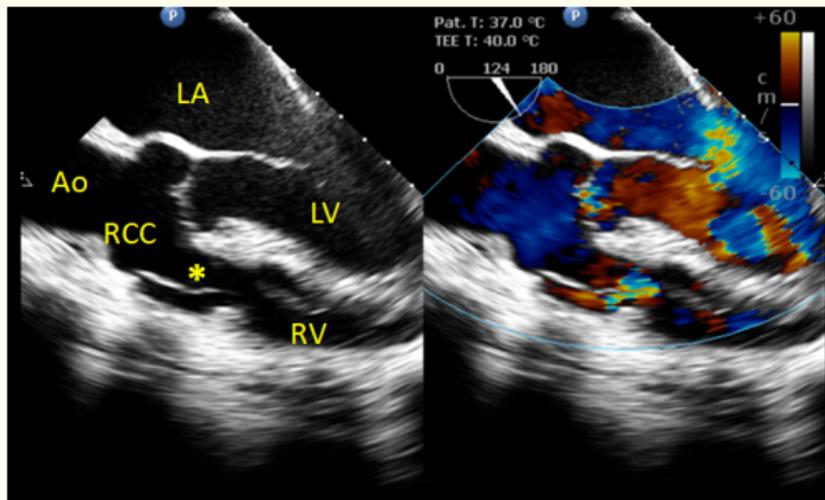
Trans esophageal echocardiogram parasternal long axis view. Left panel showing 2D echo image of rupture sinus of valsalva aneurysm arising from right coronary sinus with classical wind sock deformity. Right panel- color Doppler showing shunting of blood from right coronary sinus to right ventricle. LA: Left Atrium; LV: Left Ventricle; Ao: Aorta; RCC: Right Coronary Sinus; RV: Right Ventricle; *: Classical Windsock Deformity of RSOV.
